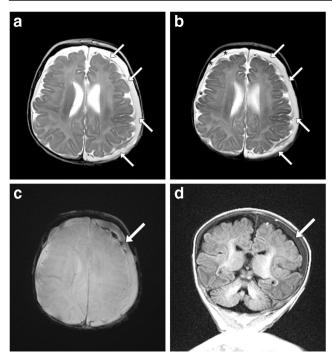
A 2.4-month-old boy in whom there is congruence between conT2FSE (conventional T2 fast spin echo) and ssT2FSE (single-shot T2 fast spin echo). Bilateral full convexity subdural hemorrhage with evolving membranes between the subdural and subarachnoid hemorrhages, left greater than right. a, b The *arrows* on the conT2FSE (a) and ssT2FSE (b) delineate a relatively thicker left-side full convexity subdural membrane; the *asterisks* (b) within the subdural space delineate a relatively thinner right-side full convexity membrane related to displaced arachnoid tissue separate from the adjacent subarachnoid space and pial surface on ssT2FSE. c, d The *arrows* demonstrate the blood product on axial gradient recalled echo (GRE) (c) and coronal T1-FLAIR (fluid attenuated inversion recovery) (d)
